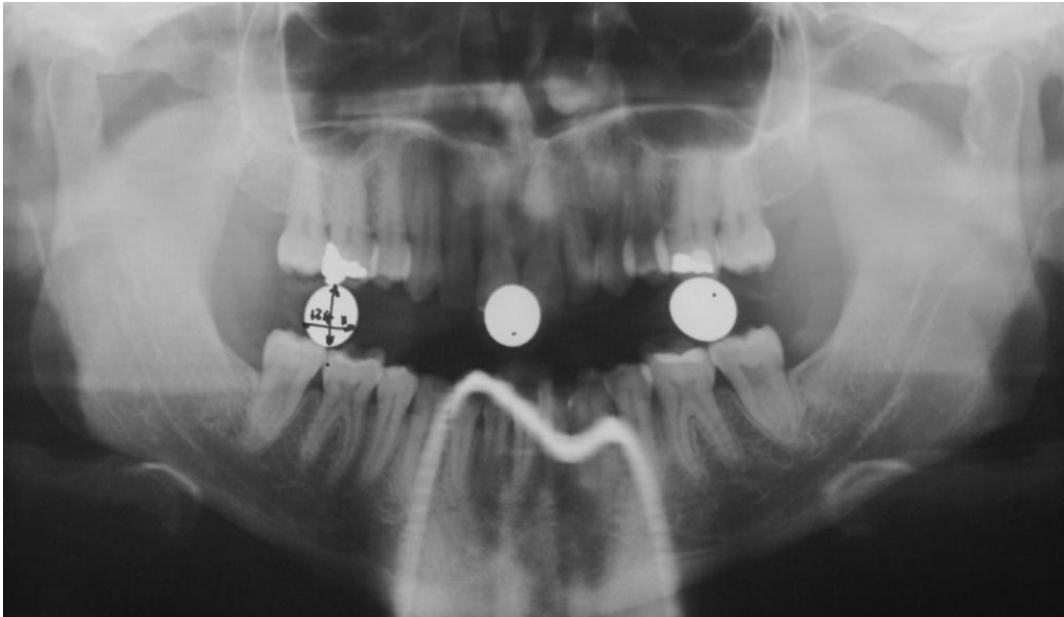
Orthopantomograph used in calculating distortion of the radiograph machine
